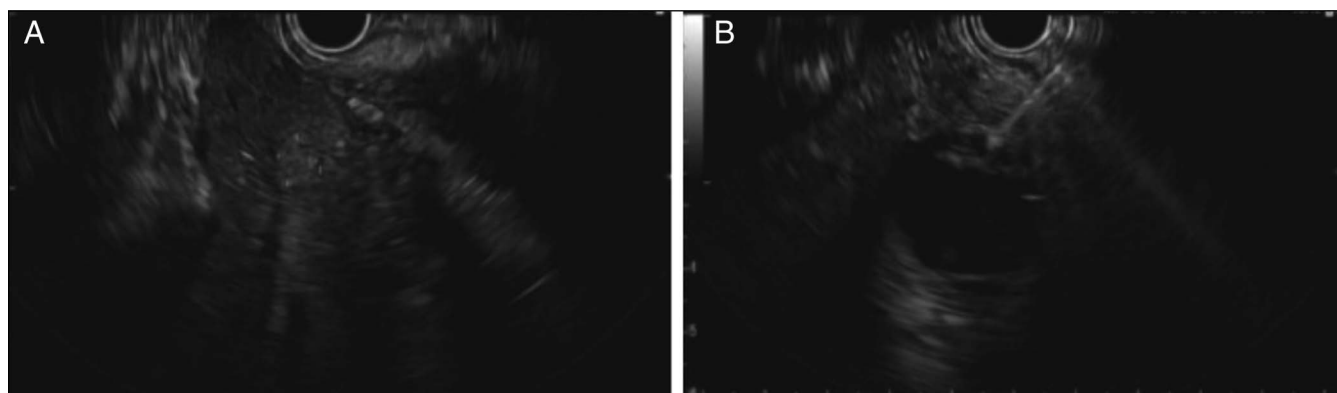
(A) EUS imaging of liver lesion in the right lobe. (B) EUS-guided fine-needle biopsy of gallbladder mass. EUS, endoscopic ultrasound.
